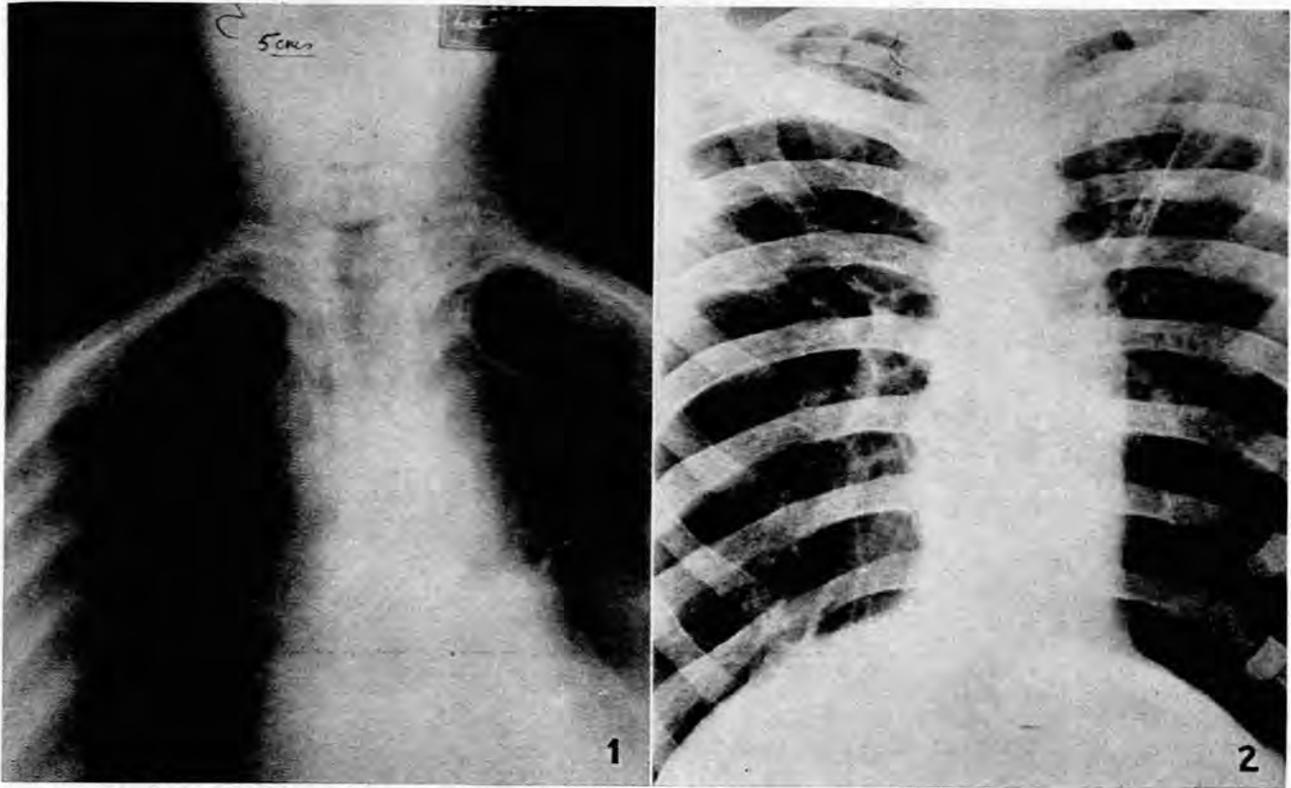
Tomogram at 5 cm. showing bilateral apical cystic cavitation. Fig. 2. Postero-anterior chest X-ray showing tuberculous cavitation in both upper lobes and emphysema of the left lower lobe.
